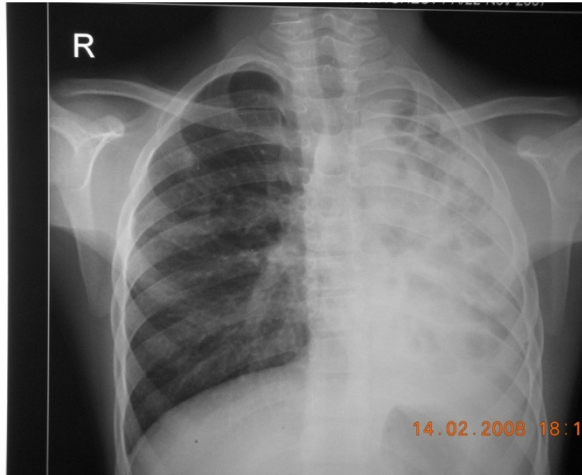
Pre operative chest radiograph showing destroyed Left lung.
